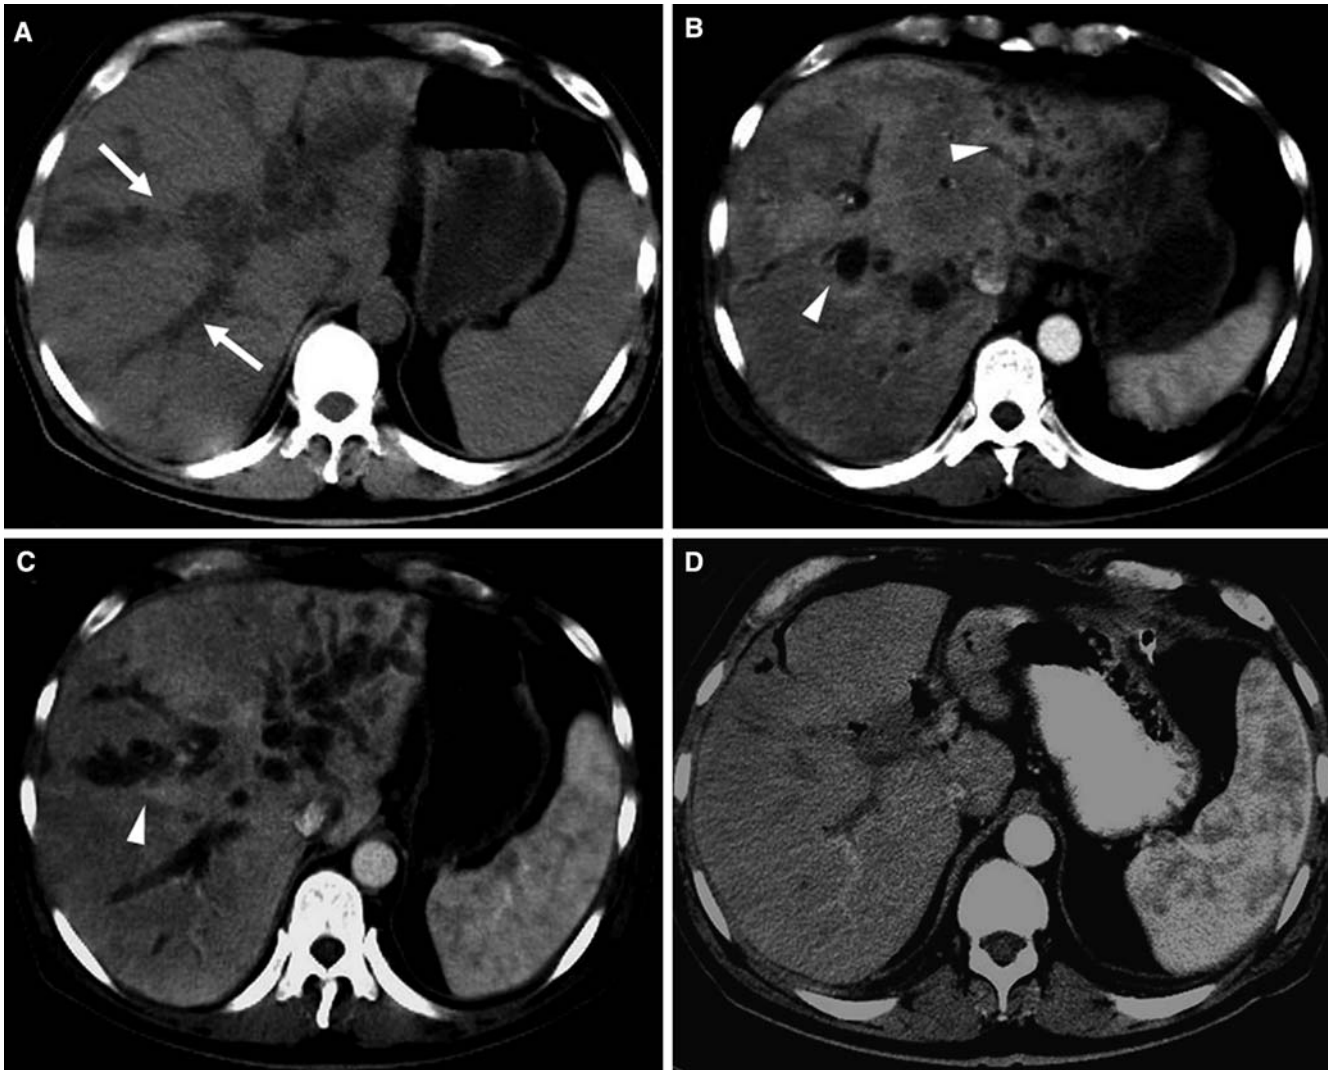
A 59-year-old man with choledochal stones. (A) Unenhanced CT scan shows intrahepatic biliary tree dilation (arrows). (B), (C) CT artery phase scans reveal THAD
